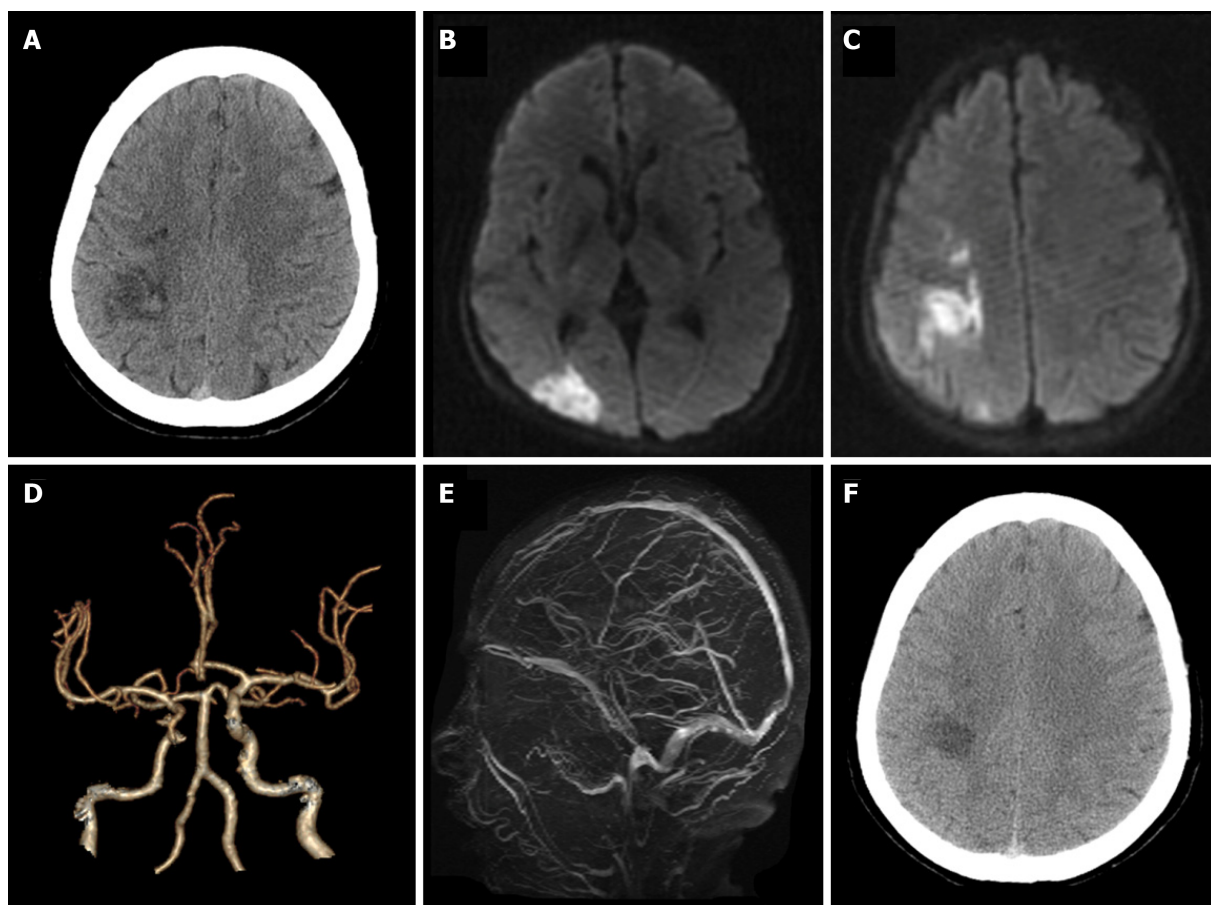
A 57-year-old woman with hemorrhagic infarction due to polycythemia vera. A: Computed tomography (CT) showed patchy high-density changes in right parietal low-density lesions; B and C: Diffusion-weighted imaging showed acute ischemia in the right parietal and occipital lobes; D: CT-angiography showed mild atherosclerosis; E: Magnetic resonance venogram was unremarkable; F: CT re-examination after 1 wk demonstrated the resolution of hemorrhage within the infarction lesion.
